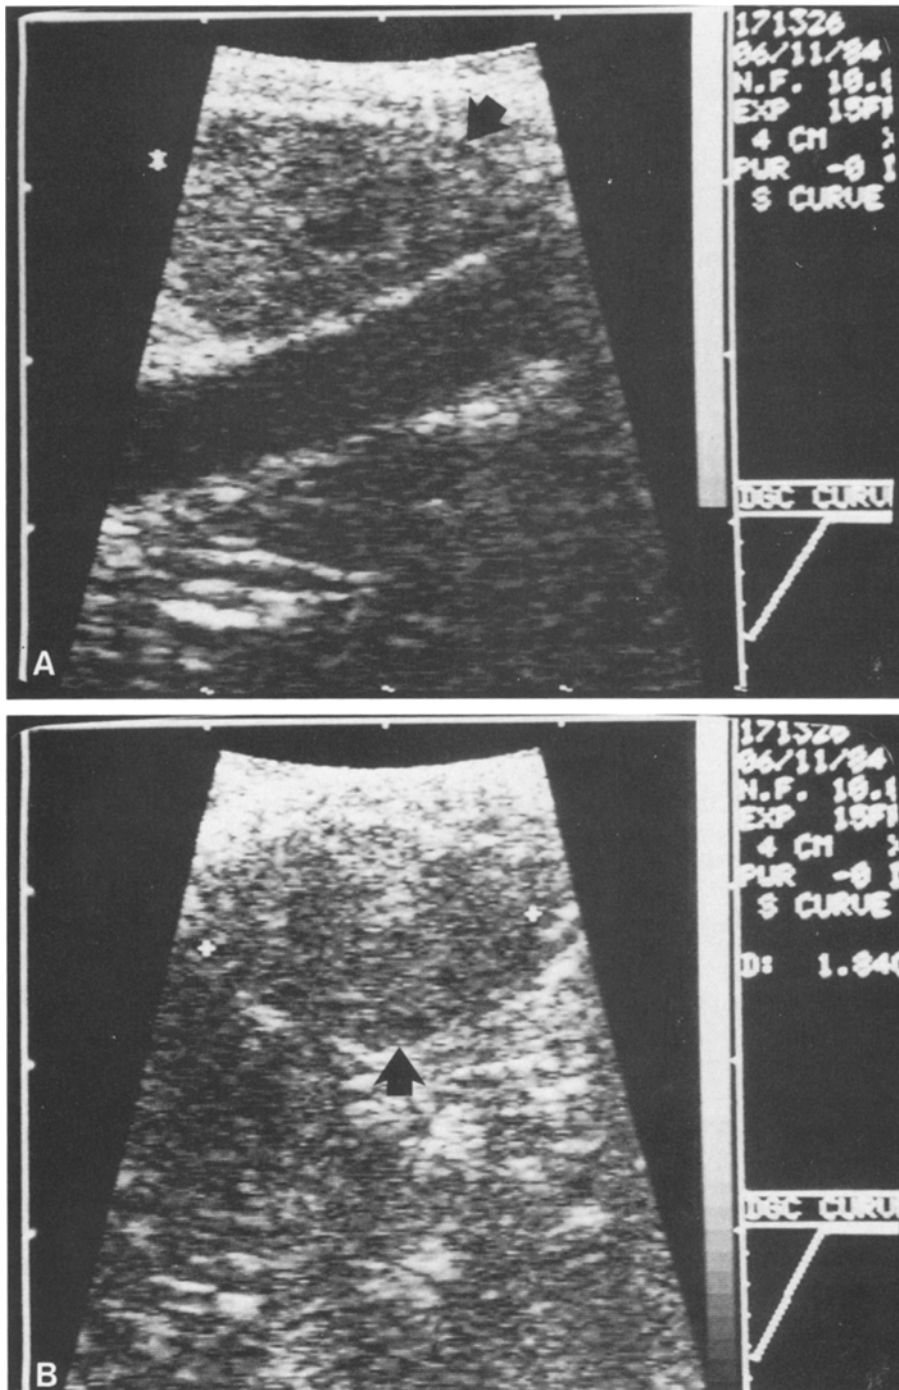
Sagittal (A) and transverse (B) intraoperative ultrasound scans of an abnormal inferior gland. Scan demonstrates importance of imaging abnormal gland in 2 dimensions. Parathyroid adenoma appears sonolucent.
